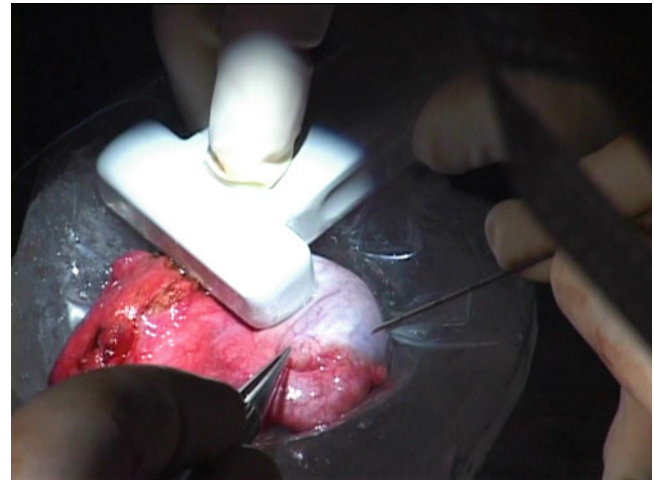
A linear ultrasound transducer at 15-MHz guides real-time intraoperative placement of the stereotaxic hook-shaped needle adjacent to the nodule. The 30-gauge stereotaxic hook-shaped needle that permits the hook to be completely contained in and pass through the needle lumen. The introducing needle can thus be optimally positioned prior to engaging the hook. The hook is ejected and released from the needle tip reforming to hook and anchoring into the tissue adjacent to the tumor
